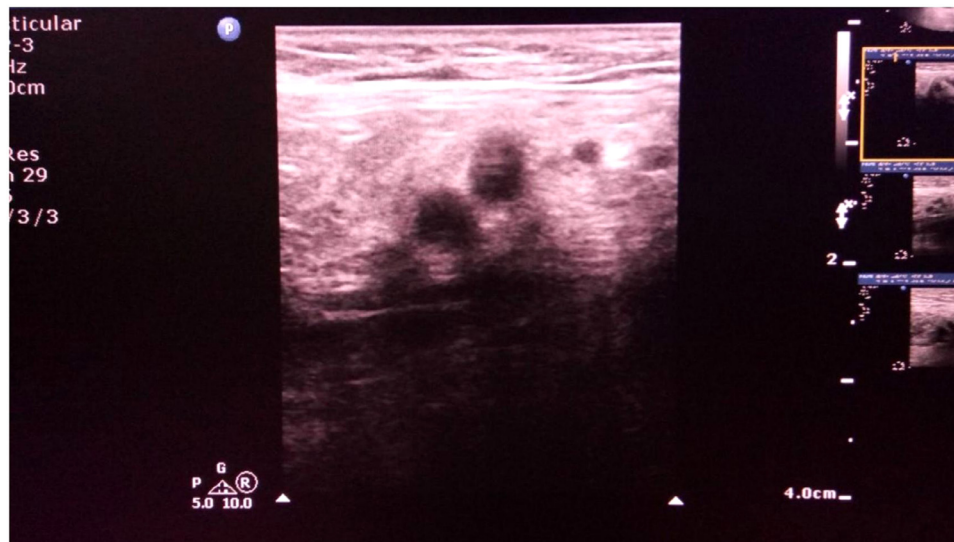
Ultrasound image of the scrotum demonstrating the efferent and afferent loops of the ureter.
